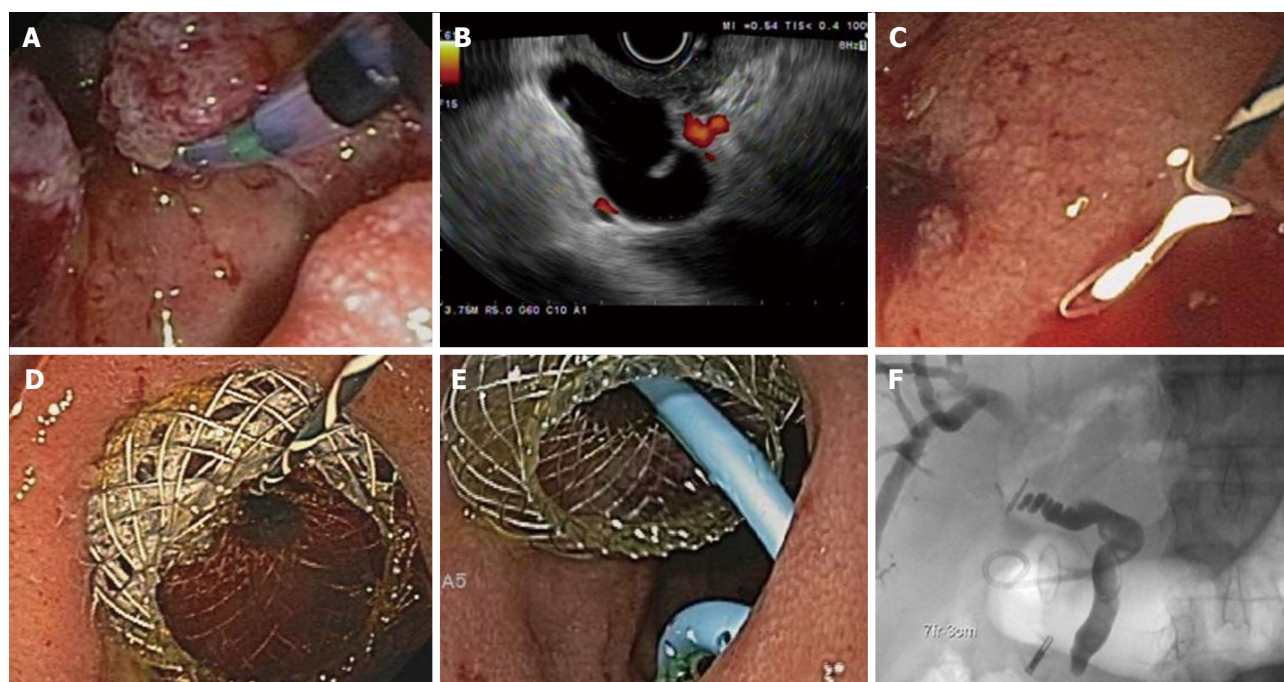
A 84 years old male with duodenal adenocarcinoma causing biliary obstruction underwent endoscopic ultrasound-guided choledochoduodenostomy following unsuccessful endoscopic retrograde cholangiopancreatography. A: Tumor involving the major papilla; B: Endoscopic ultrasound-guided puncture of the common bile duct through the duodenum with a 19-gauge needle; C: Guidewire insertion and balloon dilation of a choledochoduodenal fistula; D: Followed by the placement of a 10 mm × 10 mm lumen-apposing metal stent to create a choledochoduodenostomy; E and F: Endoscopic (E) and fluoroscopic (F) view after the placement of a 7 Fr × 3 cm double pigtail stent into the common hepatic duct.
